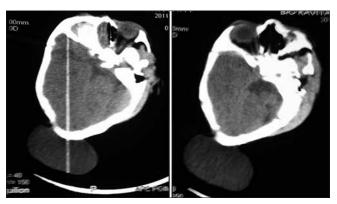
Computed tomography scan showing cystic occipital swelling
